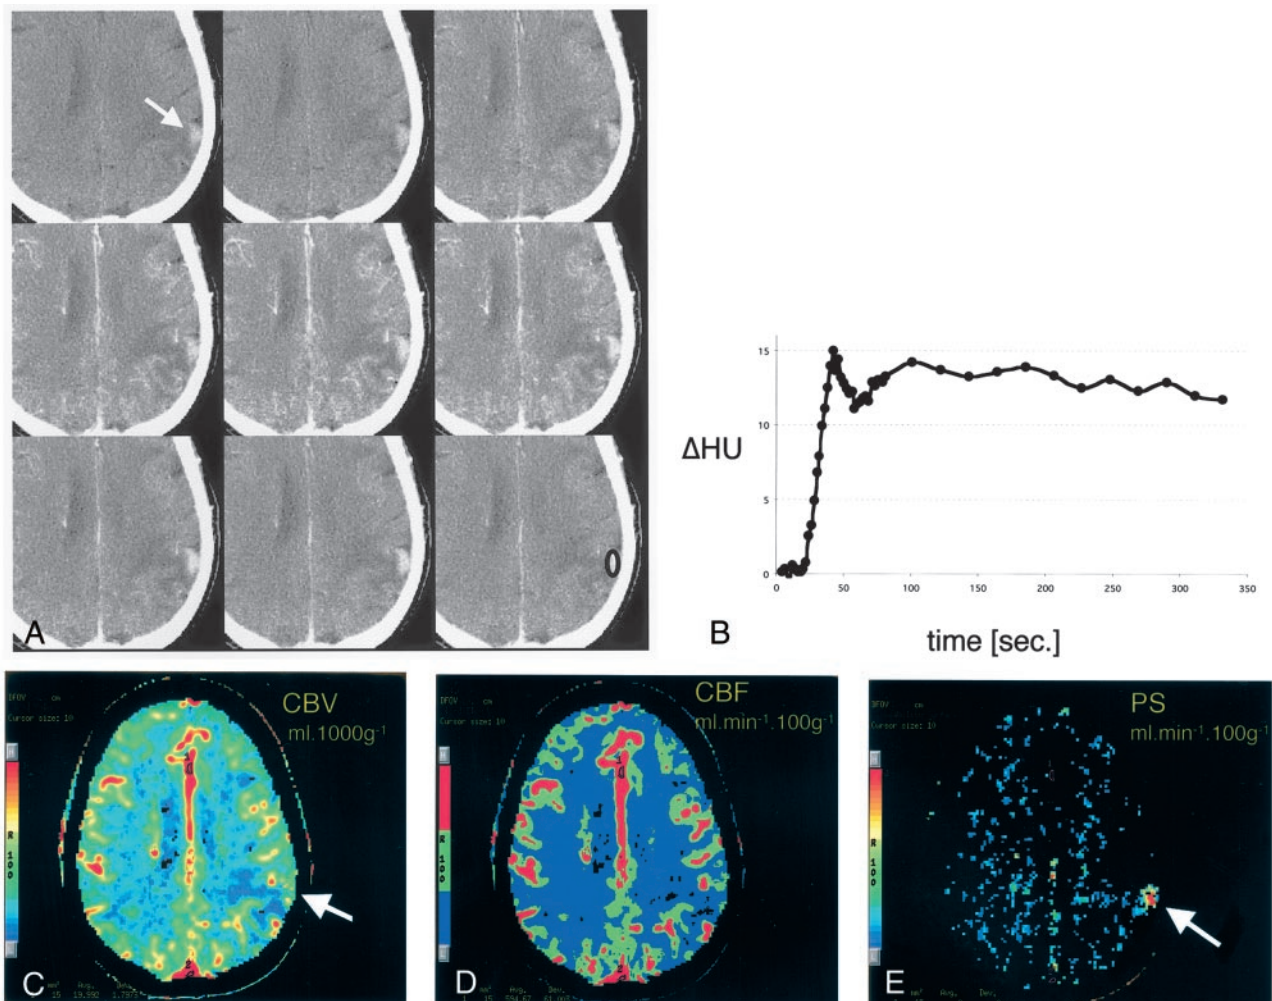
CT scans and data analysis obtained from patient 1.
